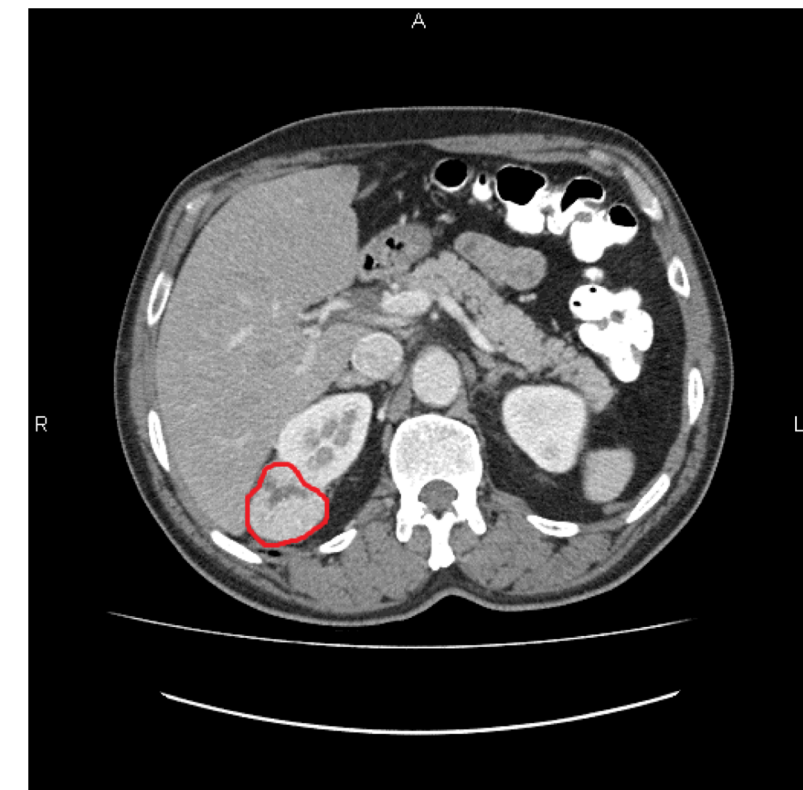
CT scan of the abdomen (tumor circled)
